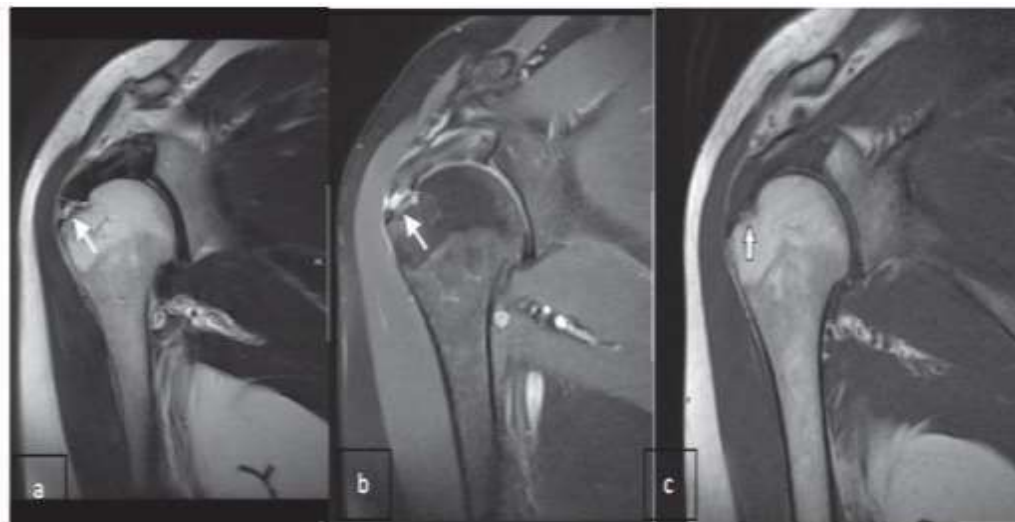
MRI (a) coronal T2, (b) coronal PDFS, (c) coronal T1WI, shows full thickness tear of supraspinatus tendon near its humeral attachment with fluid signal intensity in gaping area measuring ~ 5.0 mm.
